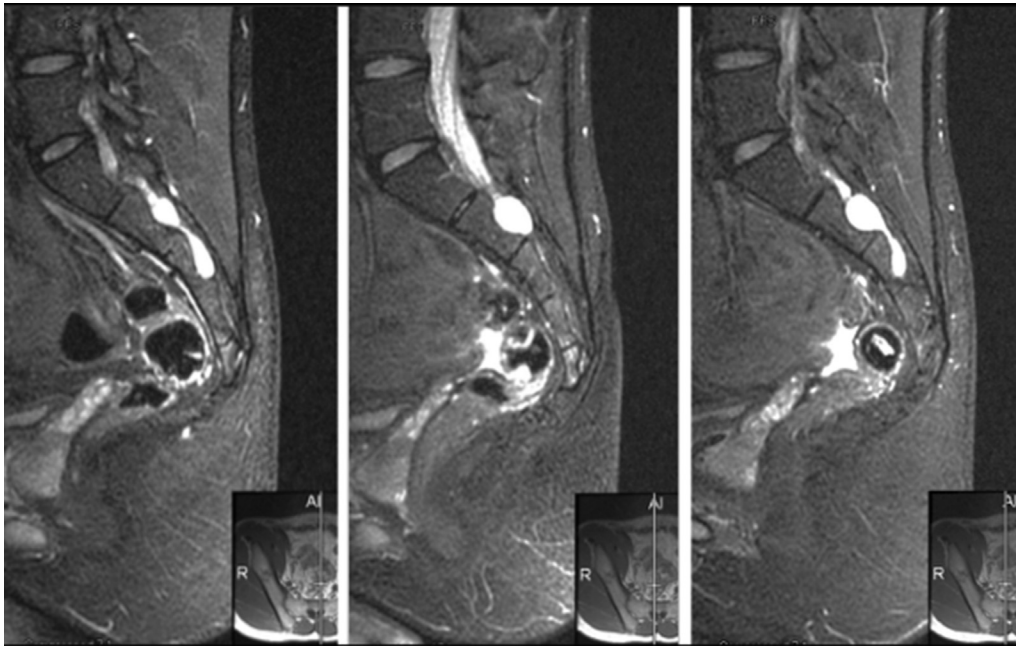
Sagittal views of the patient's multiple Tarlov cysts (white elliptical objects) at sacral levels 2 and 3 in locations relative to the midline that are shown in the corresponding small frontal images at the lower right side of each panel. The cysts appear white in these water-enhanced T2-weighted images because they contain cerebrospinal fluid.
